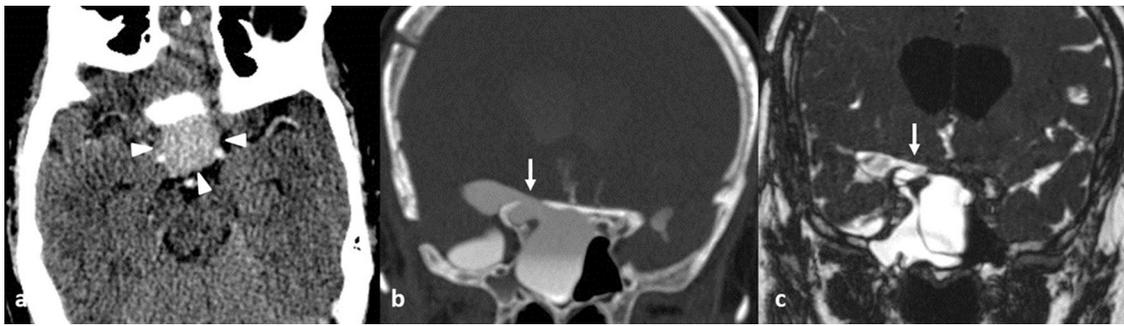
Forty-nine-year-old woman with watery nasal discharge on right side, 3 weeks after surgery for pituitary macroadenoma: a: presurgical CECT brain image in the axial plane shows well enhancing suprasellar lesion abutting bilateral internal carotid and basilar artery (arrowheads); b–c: postsurgical coronal CT and MR cisternography images shows superolateral extension of pneumatization with CSF leakage through the bony defect involving anterior clinoid process (arrow).
